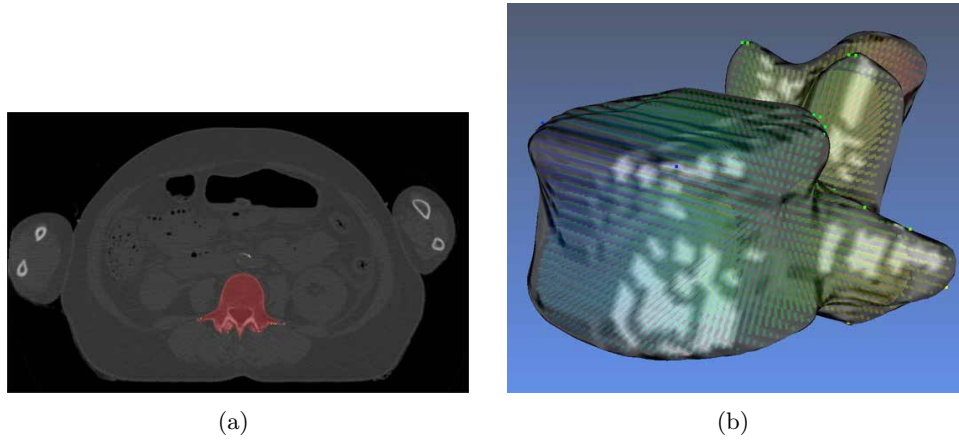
(a) A lumbar vertebra shown in red segmented from CT images. (b) 3D surface model reconstructed from point cloud data.
